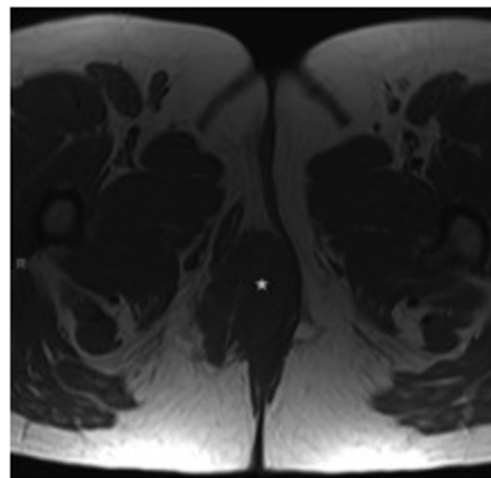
Axial, T1-weighted, precontrast image shows the 9.7 x 5 cm mass (*) in the right ischiorectal fossa, abutting the labia, to be isointense to skeletal muscle.
